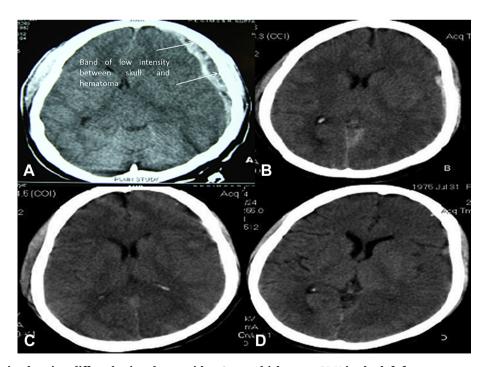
A) CT brain showing diffuse brain edema with a 9 mm thick acute SDH in the left fronto-temporo-parietal region with a midline shift of 10 mm. Arrow shows the band of hypodensity between the inner side of skull bone and the hematoma. B) Repeat CT scan showing decrease in size of SDH. C and D) Repeat CT scan at day 3 and 6 showing complete resolution of ASDH.
